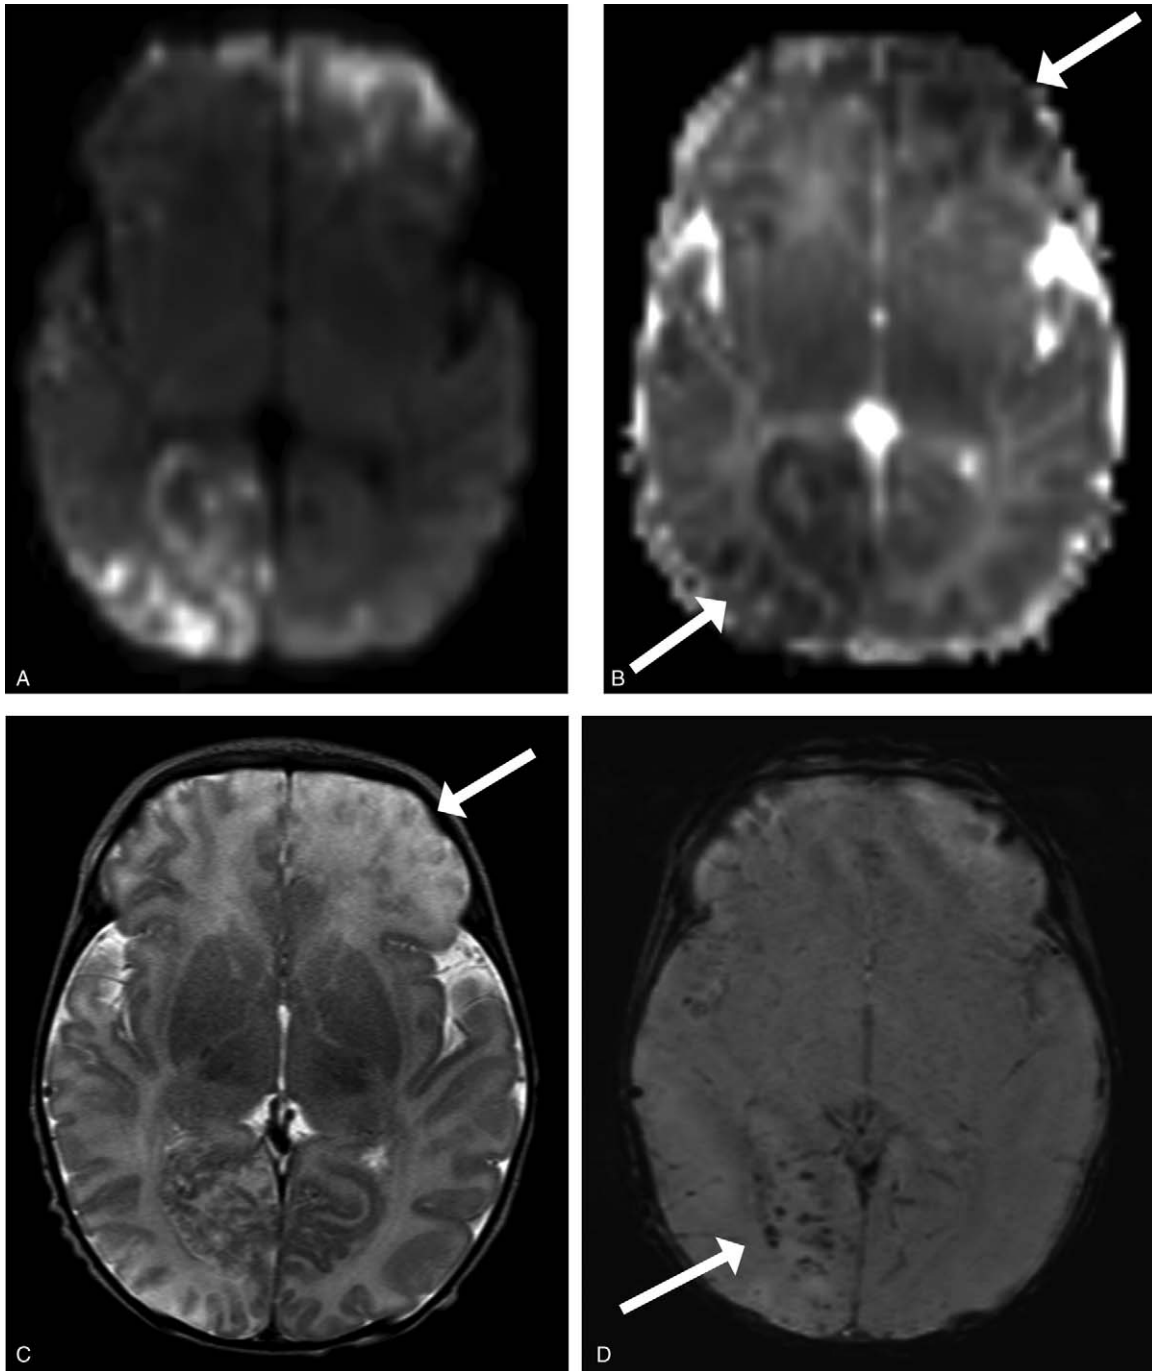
6-Year-old girl with incontinentia pigmenti. Axial diffusion-weighted imaging (DWI) (A) and ADC map (B) show multifocal parenchymal diffusion restriction involving predominantly the cortex of the left frontal and right occipital lobes, consistent with acute cytotoxic injury. Axial T2-weighted image (C) shows cortical edema in the left anterior frontal lobe. Axial SWI image (D) shows microhemorrhagic foci within the right occipital lobe.
